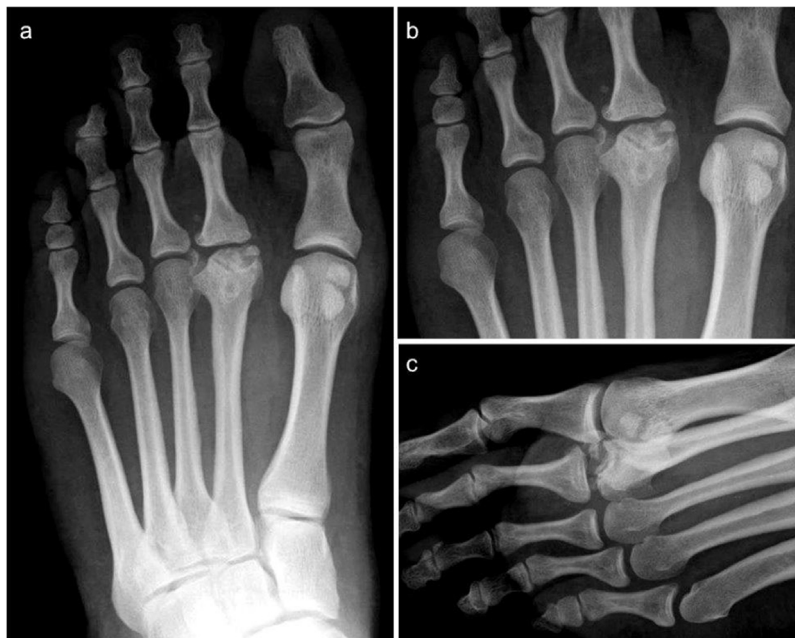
Preoperative weight bearing x-rays of the left foot: a) antero-posterior view showing an alteration of the articular surface of the head of the second metatarsal, which appears flattened and sclerotic; b) particular of the first figure of the second metatarsal head. In this figure the alteration is clearly visible and it seems that the head is fragmented; c) lateral (lateral oblique) view showing the lesion. In this figure, Freiberg's infraction grade IV could be conceivable.
